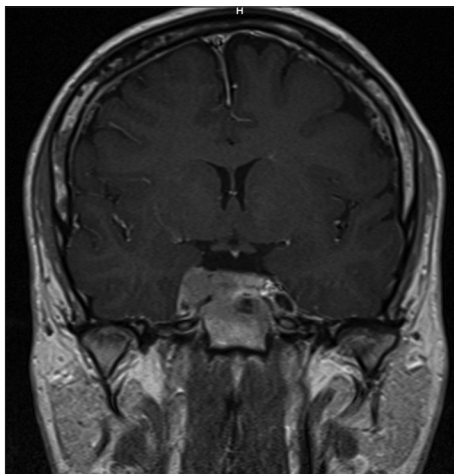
The tumor extension within the right cavernous sinus (brain magnetic resonance imaging T1-weighted image)
